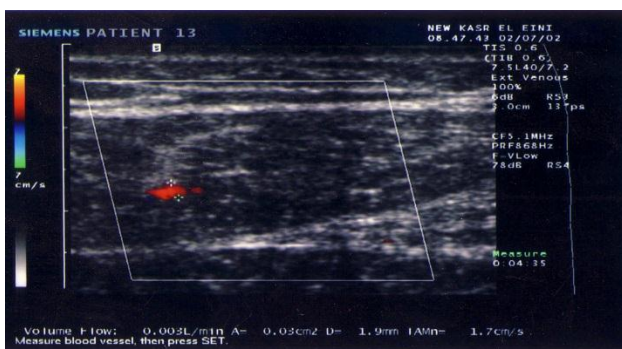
Duplex Doppler ultrasound report
